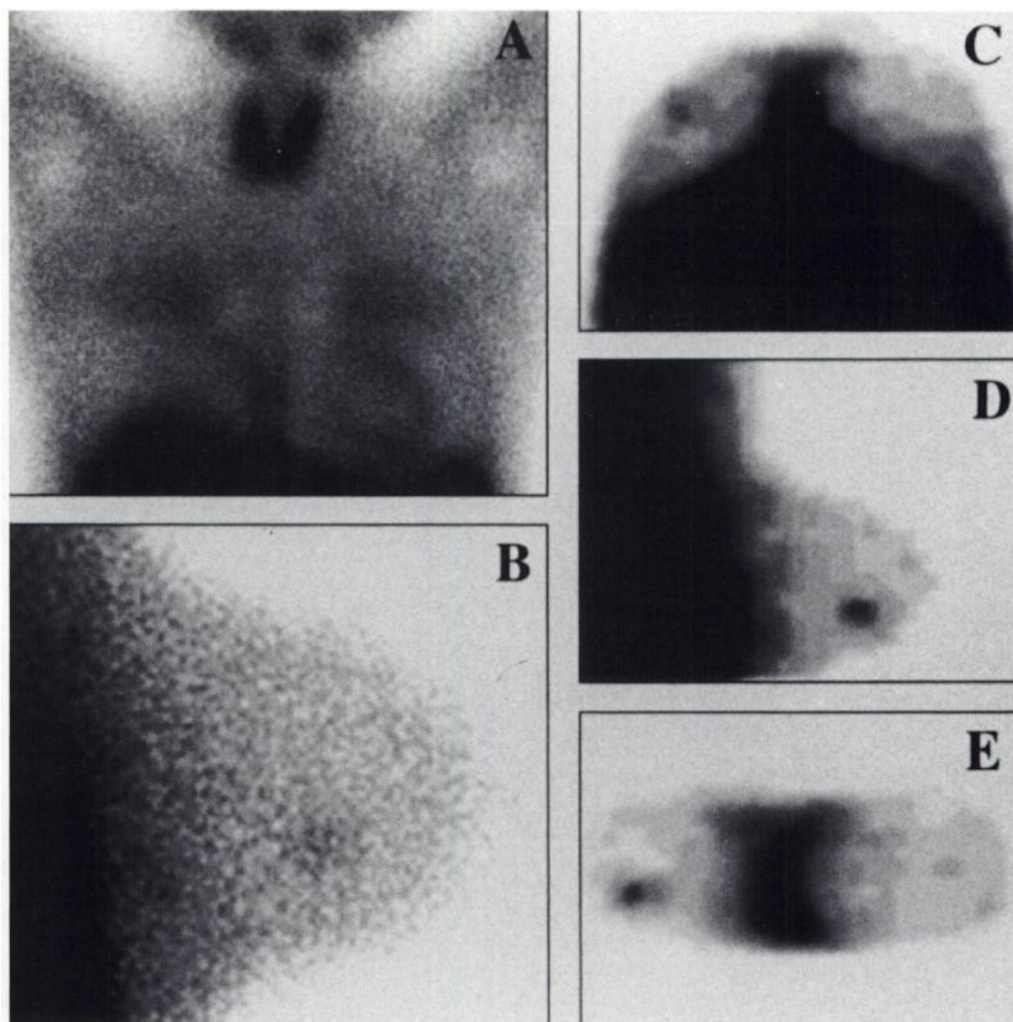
Ductal infiltrative carcinoma (pT1c). (A) Planar anterior SMM could not localize faint focal sestamibi accumulation seen on planar lateral image (B) due to superimposition of heart and background activity. ISA-SPECT demonstrated lesion more clearly as shown in transverse (C), sagittal (D) and coronal (E) slice orientations. Exact localization of tumor was possible only by SPECT.
